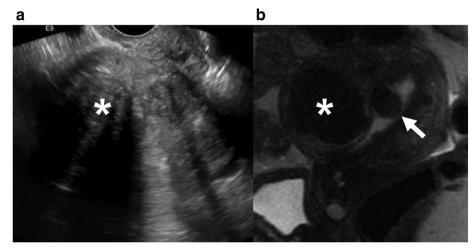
Images from a 45-year-old woman presenting with menometrorrhagia, passage of clots, and cramping. (a) Sagittal view of the uterus from a pelvic US demonstrating an enlarged uterus with multiple intramural fibroids with a large anterior fibroid (white asterisk) causing attenuation and poor acoustic penetration. (b) Sagittal T<sub>2</sub>-weighted single-shot fast spin echo image from a pelvic MRI performed 6 days after the US showing a myomatous uterus including the large anterior intramural fibroid (white asterisk) as well as an endocavitary fibroid (white arrow), which was likely responsible for the patient's symptoms. This endocavitary fibroid was amenable to hysteroscopic myomectomy.
